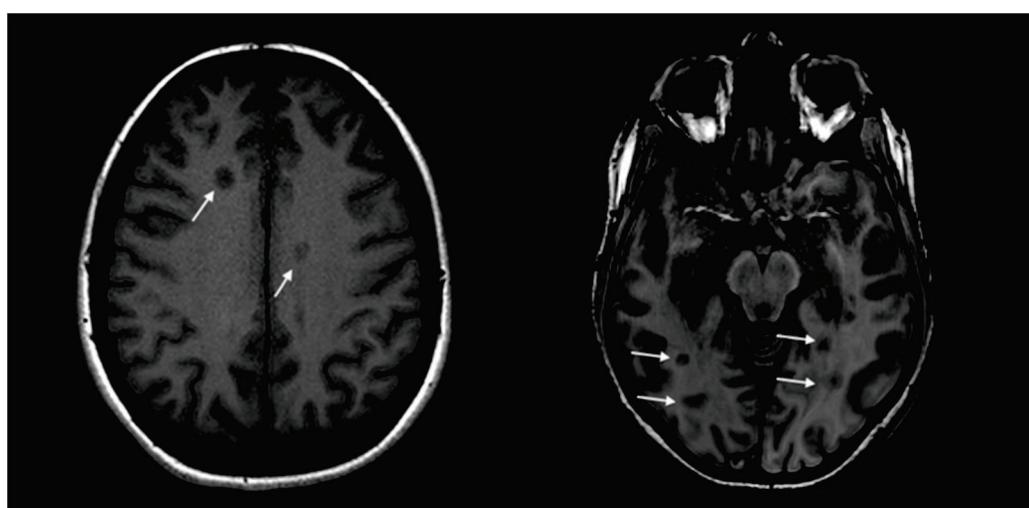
Onset MRI scans of two enrolled patients. The white arrows indicate T1 hypointense lesions, known as black holes.
